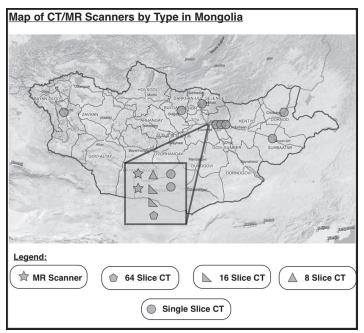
Distribution of advanced cross-sectional imaging capabilities in Mongolia. Of the 14 computed tomography (CT) scanning units, six are in the capital city, Ulaanbaatar. Five of six units capable of writing to compact discs are also located in Ulaanbaatar. For multi-detector CT scanners with two or more channels, 1.25mm slice thickness and 1mm reconstruction intervals are possible. There are two magnetic resonance imaging units in Mongolia, also located in Ulaanbaatar. Red lines depict the regional borders of the aimags (states) comprising Mongolia and do not represent roads. (Map provided courtesy of Dr. M. Saandari, MONMAP Engineering Services, Ulaanbaatar, Mongolia)
